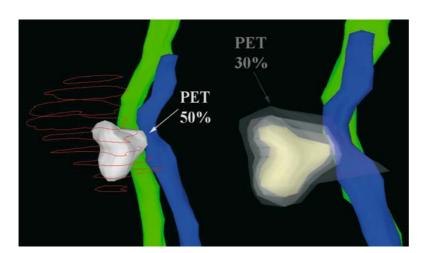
The location and size of the PET tumor volume at the 50% (of maximum intensity) threshold (displayed in solid white) vs. the CT-defined tumor volume in *red* (*left*). PET volumes at various threshold values ranging from 30% to 60% of the maximum intensity value (*right*). (Image courtesy of Dr. Samir Narayan, University of Michigan)
